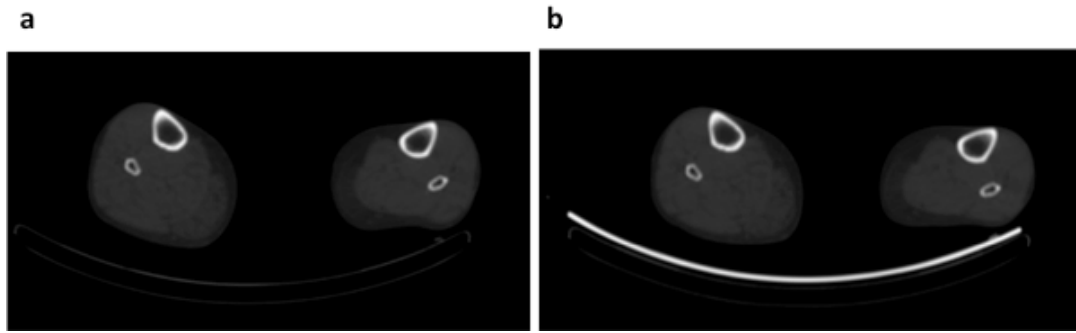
Comparison of corresponding rest (panel a) and stress (panel b) axial images of the calves of Patient E. Panels a (CT slice 32 of 119) and b (CT slice 40 of 119).
